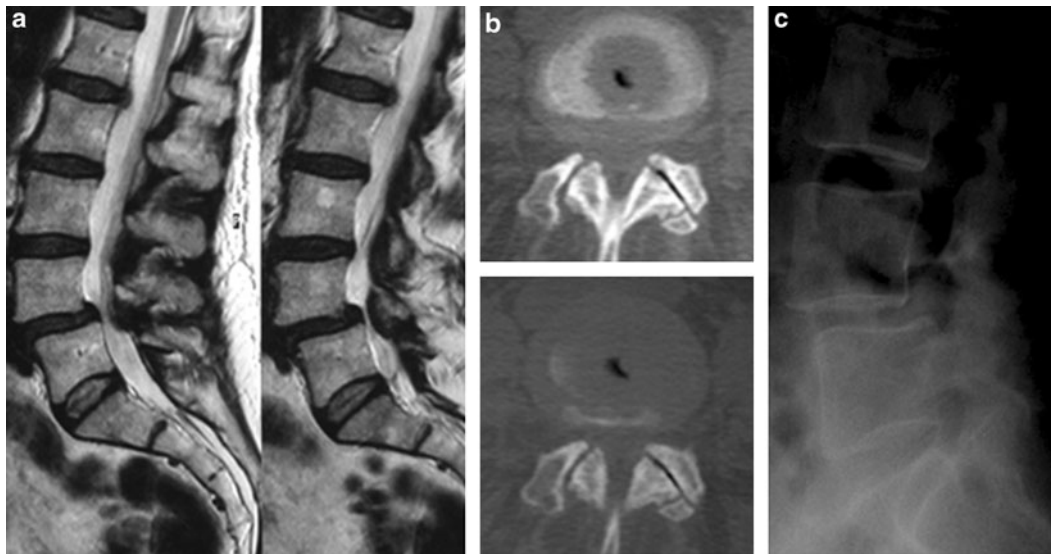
Imaging of the spinal instability. Sagittal T2-weighted images demonstrate L4-L5 discopathy and L1-L2 herniated disc; the associated decreased antero-posterior canal dimension is suspected for spondylolisthesis (a). Axial CT demonstrating a zygapophyseal subluxation (b). Dynamic orthostatic X-ray confirms L4-L5 instability (c)
